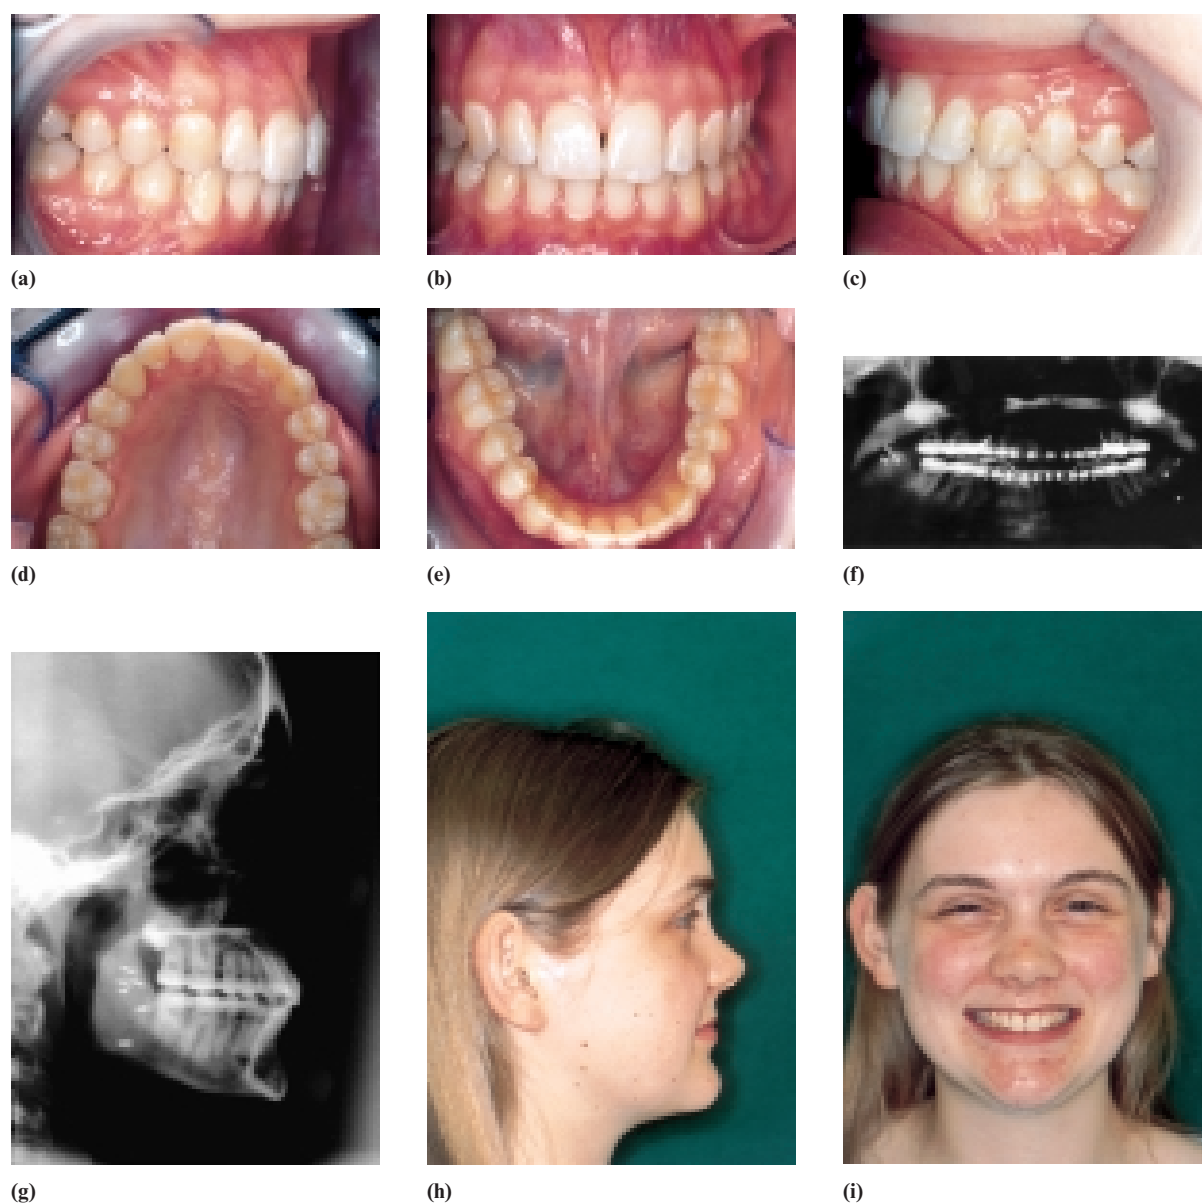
(a-l) Case report 3: post-treatment records. (a-e) Intra-oral views. (f) Panoramic radiograph. (g) Lateral skull radiograph. (h-i) Extra-oral views. (j) Cephalometric tracing. (k) Superimposition of pre-treatment (black) and post-treatment (red) cephalometric tracings on De Coster's line. (l) Maxillary and mandibular superimposition of pre-treatment (black) and post-treatment (red) cephalometric tracings on Björk's reference structures.
